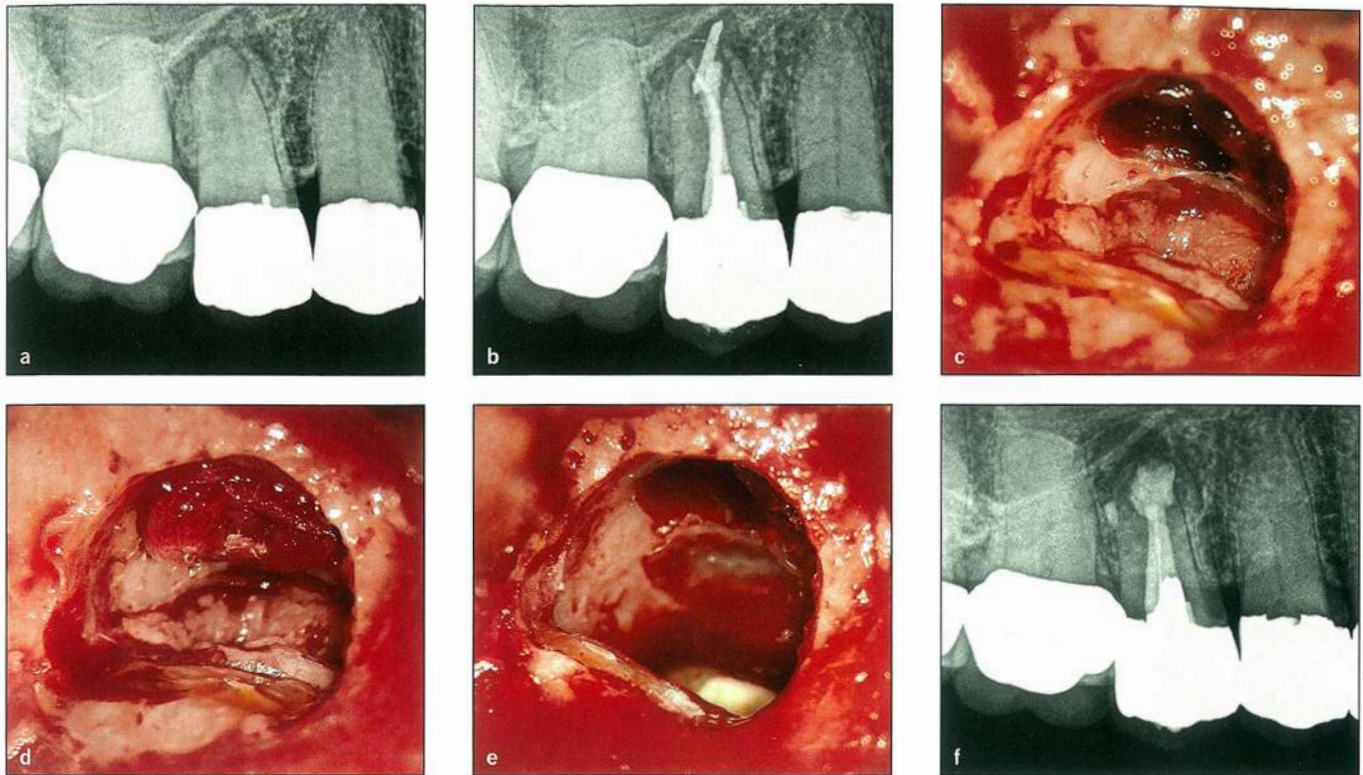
Sinus perforation during periapical surgery. (a) Preoperative periapical radiograph of a three-canal maxillary right second premolar with a calcified DB canal and inflammatory resorption of the palatal root apex. (b) Periapical radiograph of the orthograde root canal treatment with overextension of root canal filling material. (c) Surgical osteotomy and buccal root resection exposes a perforation into the maxillary sinus. (d) Iodine gauze placed over the defect to prevent surgical debris from entering the maxillary sinus. (e) Removal of the gauze following placement of bioceramic retrofillings. (f) Postoperative periapical radiograph of the completed orthograde and surgical endodontic treatment.
